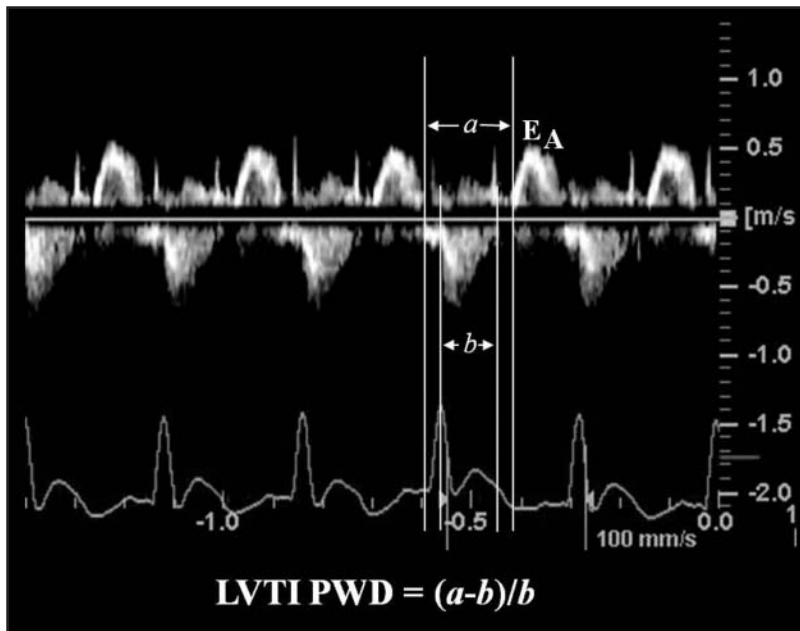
Pulsed-wave Doppler imaging recording used to determine LVTI in a New Zealand White rabbit. Value *a* is measured from the trailing edge of late diastolic mitral PWD flow A wave to the leading edge of subsequent early diastolic mitral PWD flow E wave. Value *b* is obtained by measuring the interval between the leading and trailing edges of left ventricular outflow systolic PWD tracing.
